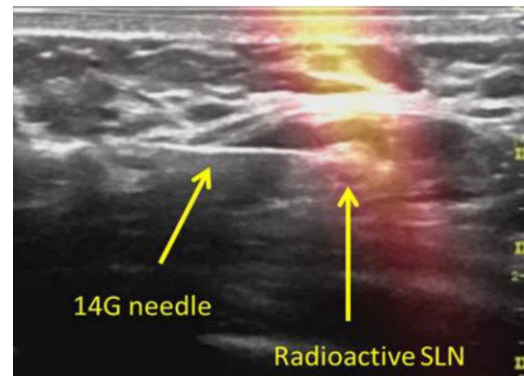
US image, the SPECT augmented SLN can be clearly differentiated and enable a needle biopsy [17].
